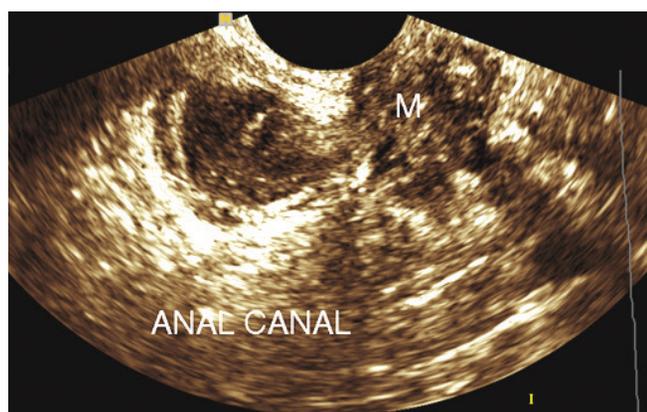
Transvaginal ultrasound of perianal endometrioma of solid pattern (M) seen infiltrating the external and internal anal sphincters of the anal canal
